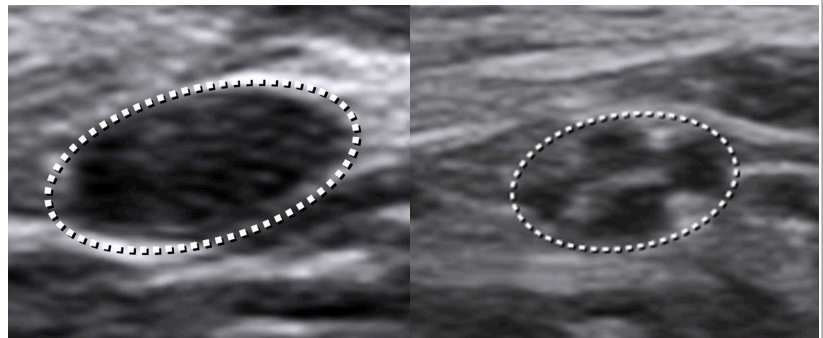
The left panel shows ultrasound of the ulnar nerve at the elbow of a patient with mild ulnar neuropathy at the elbow. The nerve is enlarged, less echogenic (darker) and has lost the normal fascicular architecture as compared with a normal ulnar nerve at the elbow shown on the right
